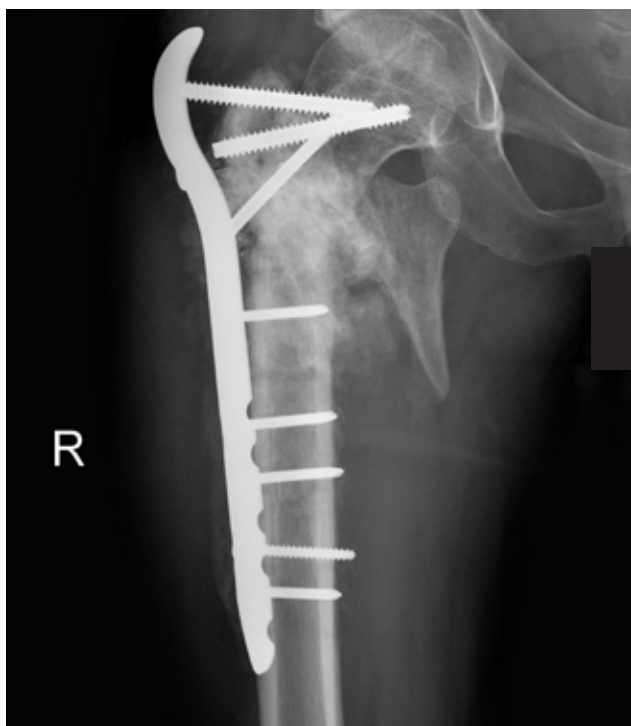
Revision to proximal femoral locking plate. Anteroposterior radiograph at 3-weeks postoperative shows failure at the screwhead/shaft interface.
